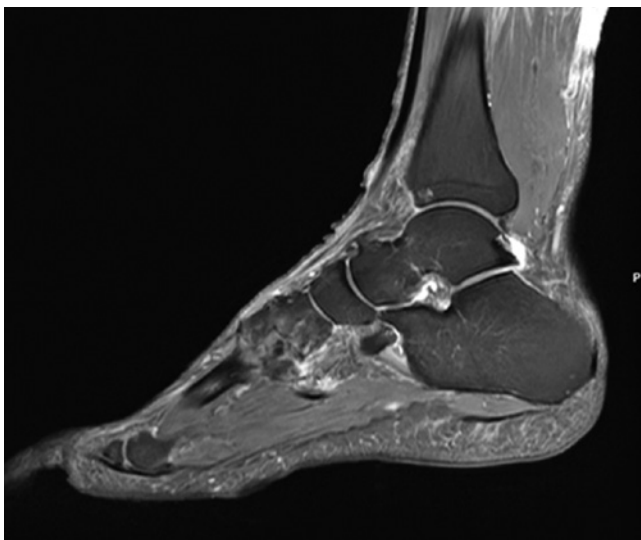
Five-year follow-up magnetic resonance imaging (density proton sagittal view) showing os supranaviculare and bone oedema of the tarsometatarsal joint.
